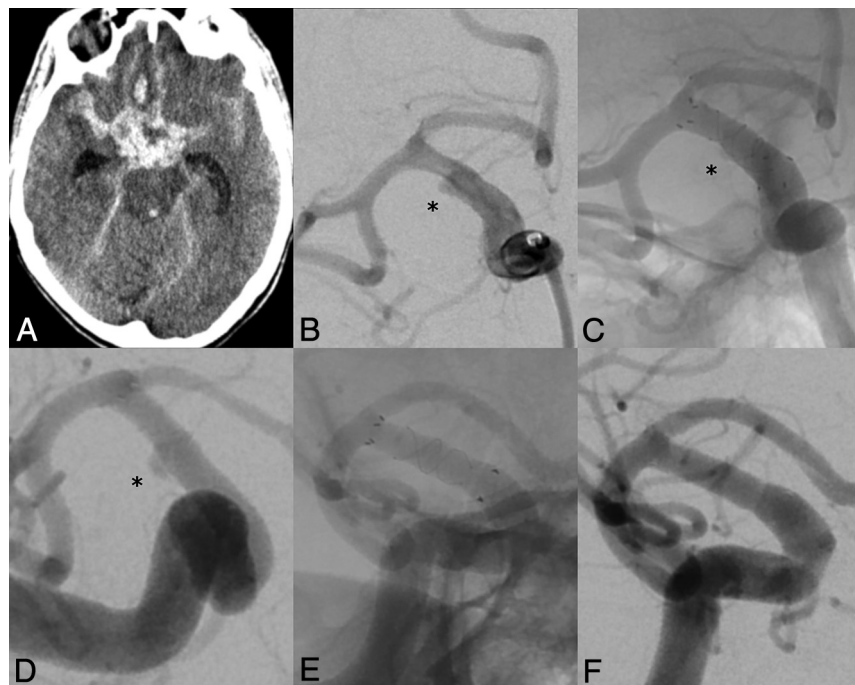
A, Nonenhanced head CT of a female patient in her 50s showing subarachnoid hemorrhage, Hunt and Hess grade 4, and Fisher grade 4. B, Angiography reveals a blister-like aneurysm of the right supraclinoid ICA with a maximum neck diameter of 3.3 mm. C, Angiographic result immediately after deployment of FRED 4.0 × 13 mm. D, Follow-up angiography at day 17 shows a residual aneurysm filling. E and F, Follow-up angiography at 3 months demonstrates complete aneurysm obliteration. mRS score at 3 months was 1.
